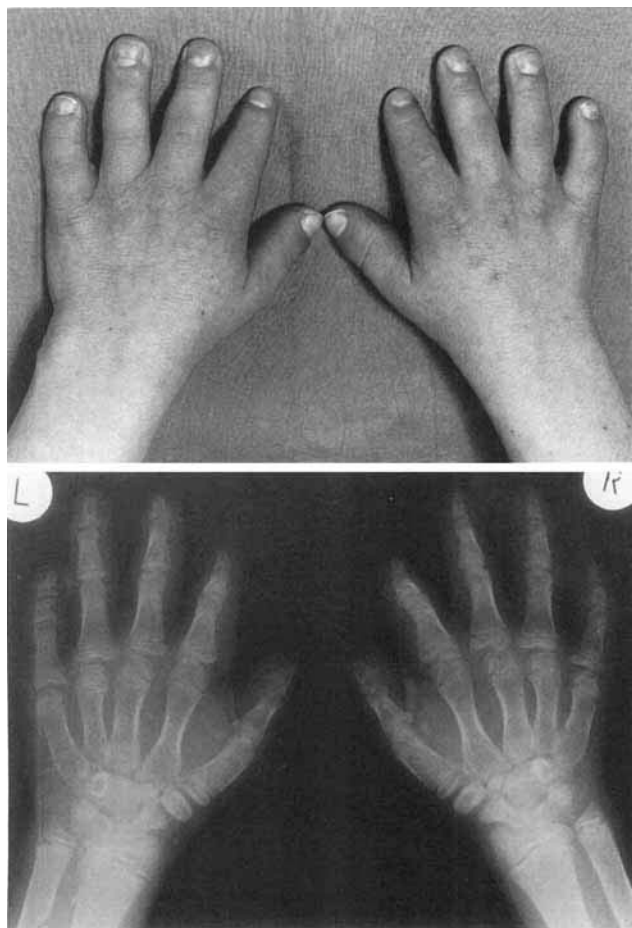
Patient 1, photograph and radiographs of the hands.
